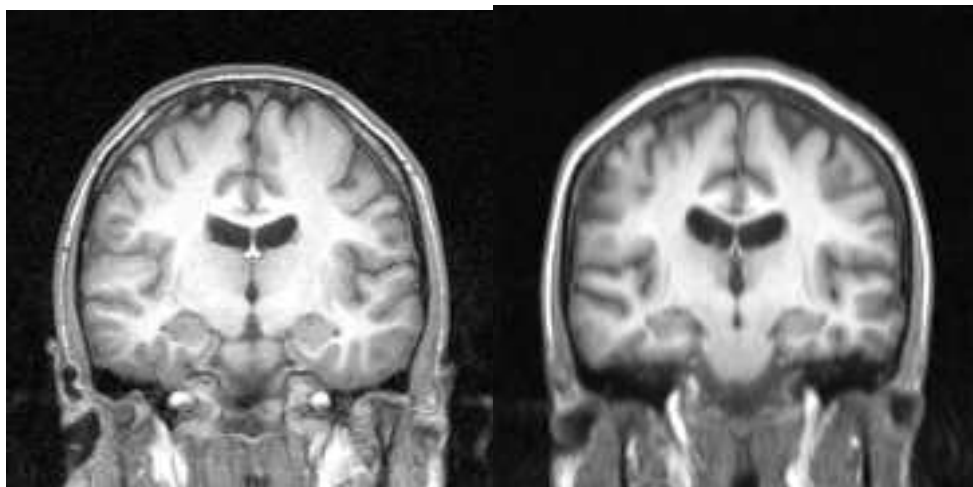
Original and smoothed MRI images; left image is the original image, whilst the right image is the smoothed image.
